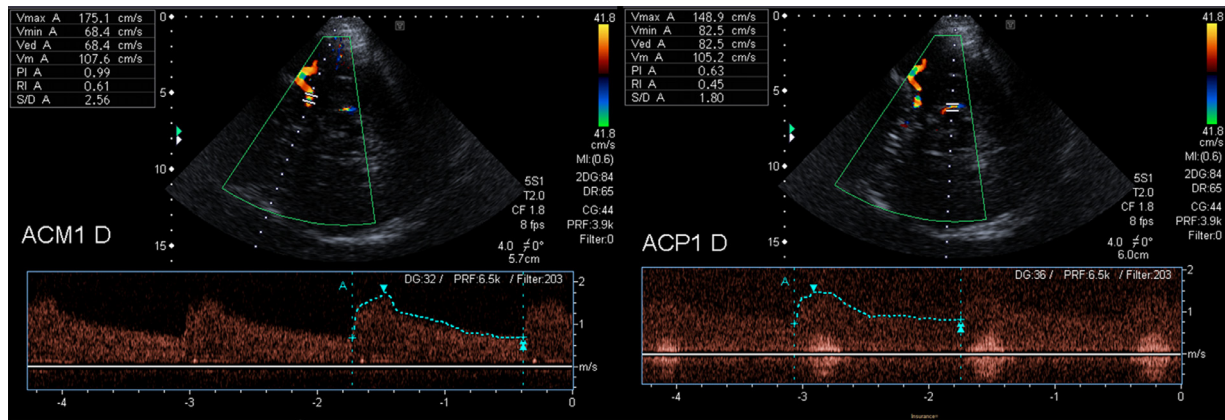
Sonography study shows turbulent flow with focal increase in velocity in right middle cerebral artery (left image) and in posterior cerebral artery (right image).
